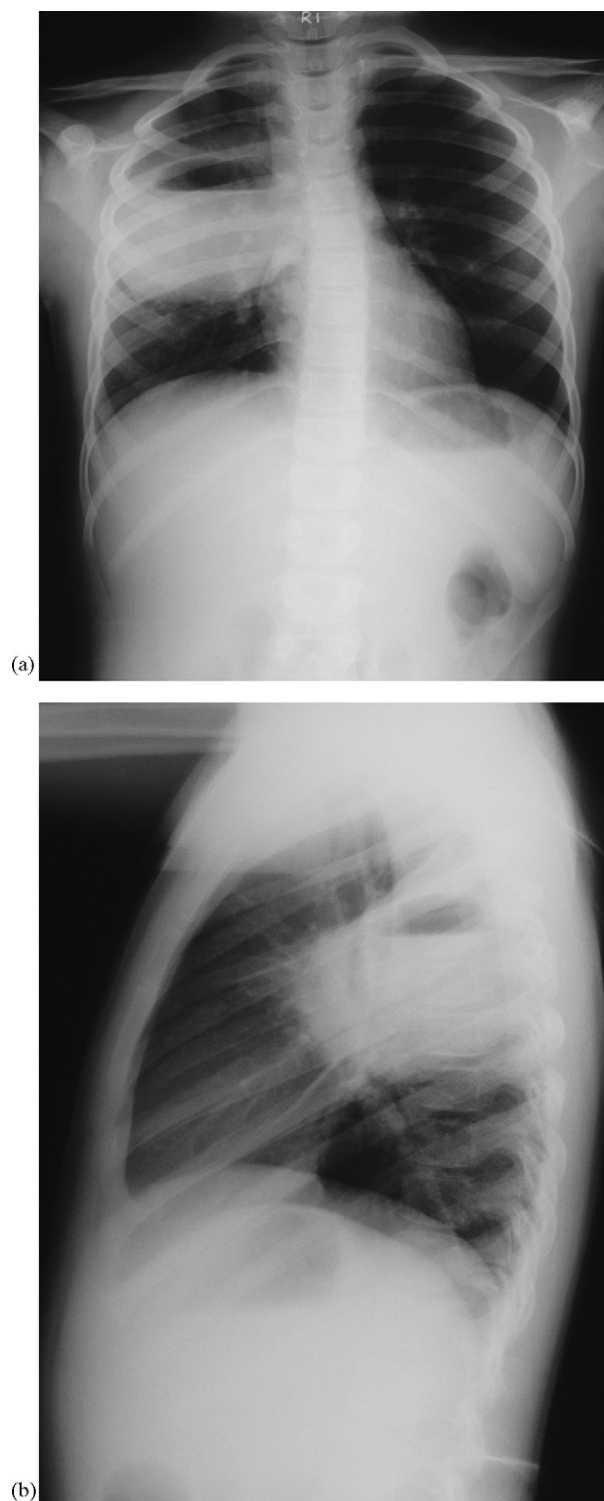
(a, b) Posteroanterior and lateral chest radiographs showing an 8 cm diameter lung abscess with an air–fluid level in the right mid-zone.
